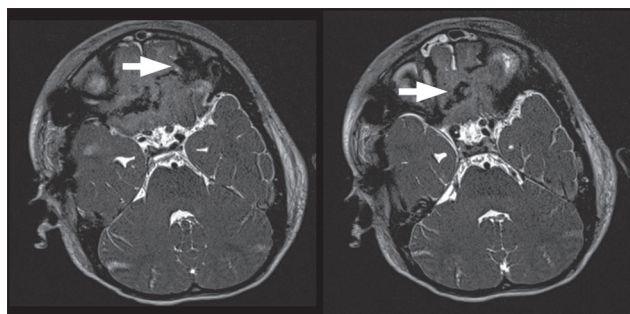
MRI CISS image showing the track traveling from the left orbit toward the right middle cerebral artery (arrows indicate the track).
